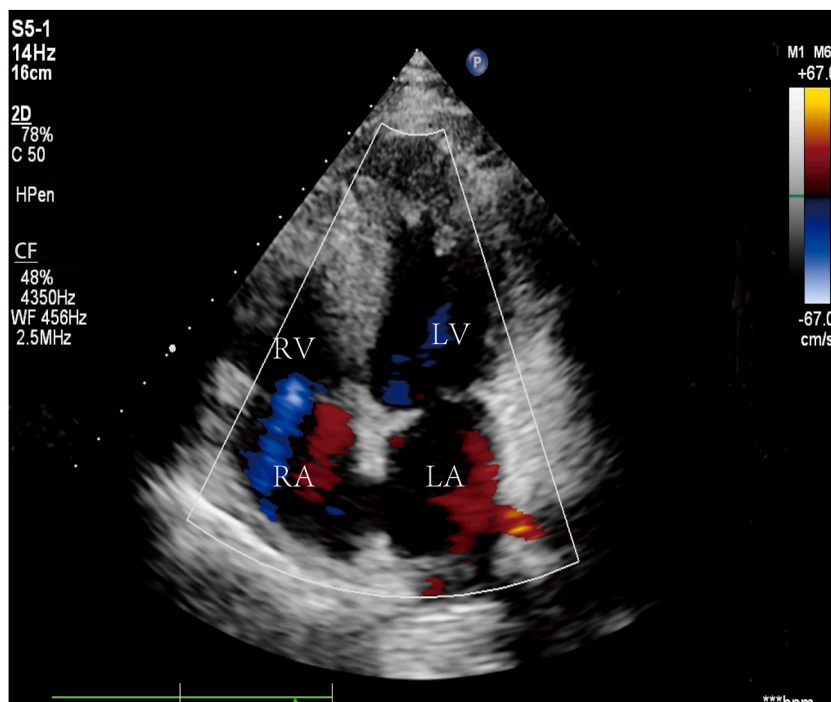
Transthoracic echocardiogram
